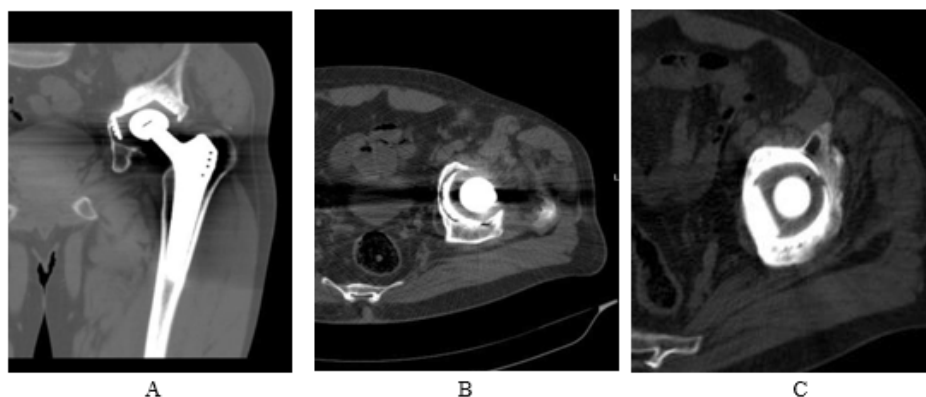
Computed tomography of the left hip (a, coronal; b, transverse), showing loosening of the cup and an acetabular defect. C Transverse image, showing supra-acetabular osteolysis.
